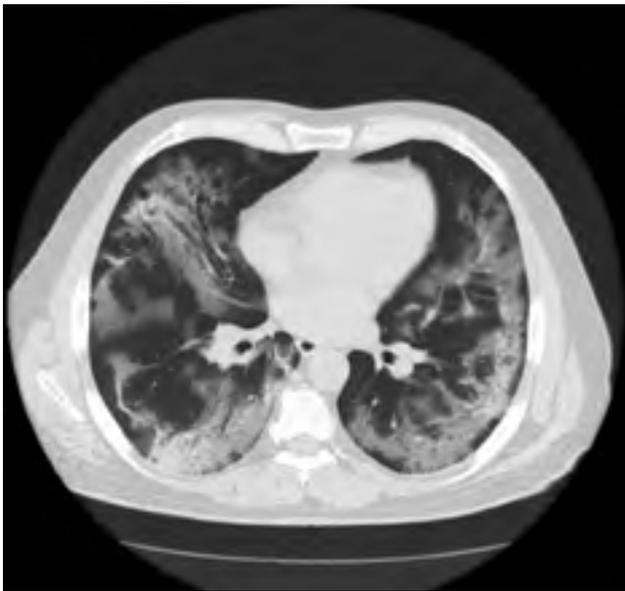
Evaluation of COVID-19 patient in axial section by high resolution computed tomography imaging.
